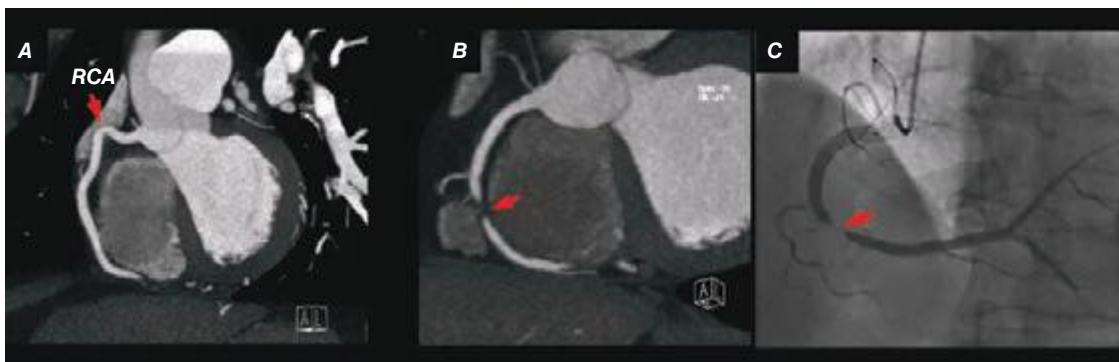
18 Representative coronary computed tomography angiographic (CTA) images of two patients presenting to the emergency department with chest pain and negative biomarkers. The patient in A had angiographically normal coronary arteries; the panel shows a representative view of the right coronary artery (RCA). B and C show a corresponding significant stenosis in the mid portion of the RCA on both the CTA (B) and invasive angiographic view (C). (Images courtesy of Dr. Quynh Truong, Massachusetts General Hospital, Boston, MA.)
